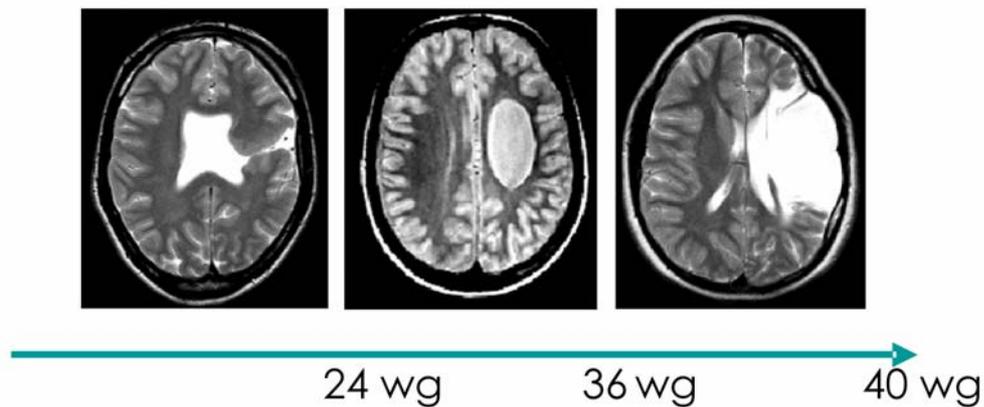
Patterns of brain damage typical for different gestational ages; examples show unilateral lesions. wg = weeks of gestation. From left to right: Malformation (schizencephaly), typical for the first and second trimester; periventricular lesion, typical for the early third trimester; cortico-subcortical infarction, typical for the late third trimester and term. T2-weighted images of adult patients who participated in studies of the *SFB 550-C4* research project.
